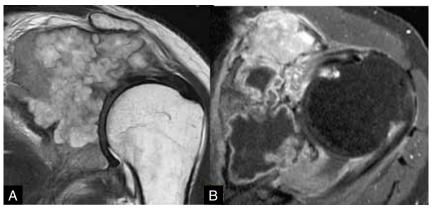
Coronar T2-weightes magnetic resonance imaging shows a lobulated tumour with mainly high-signal intensity (A). The transversal T1-weighted image (B) obtained after intravenous administration of contrast material reveals the epithelioid osteosarcoma and the extent of soft-tissue and joint-space involvement; note the necrotic area within the tumour without contrast enhancement (arrows).
